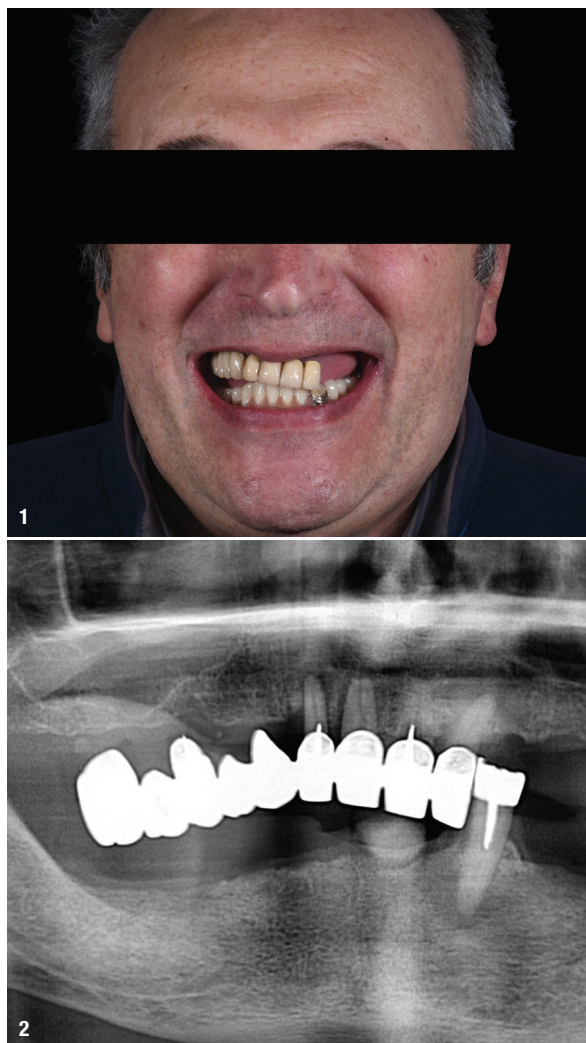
Pre-op smile. Fig. 2: Pre-op panoramic radiograph.
